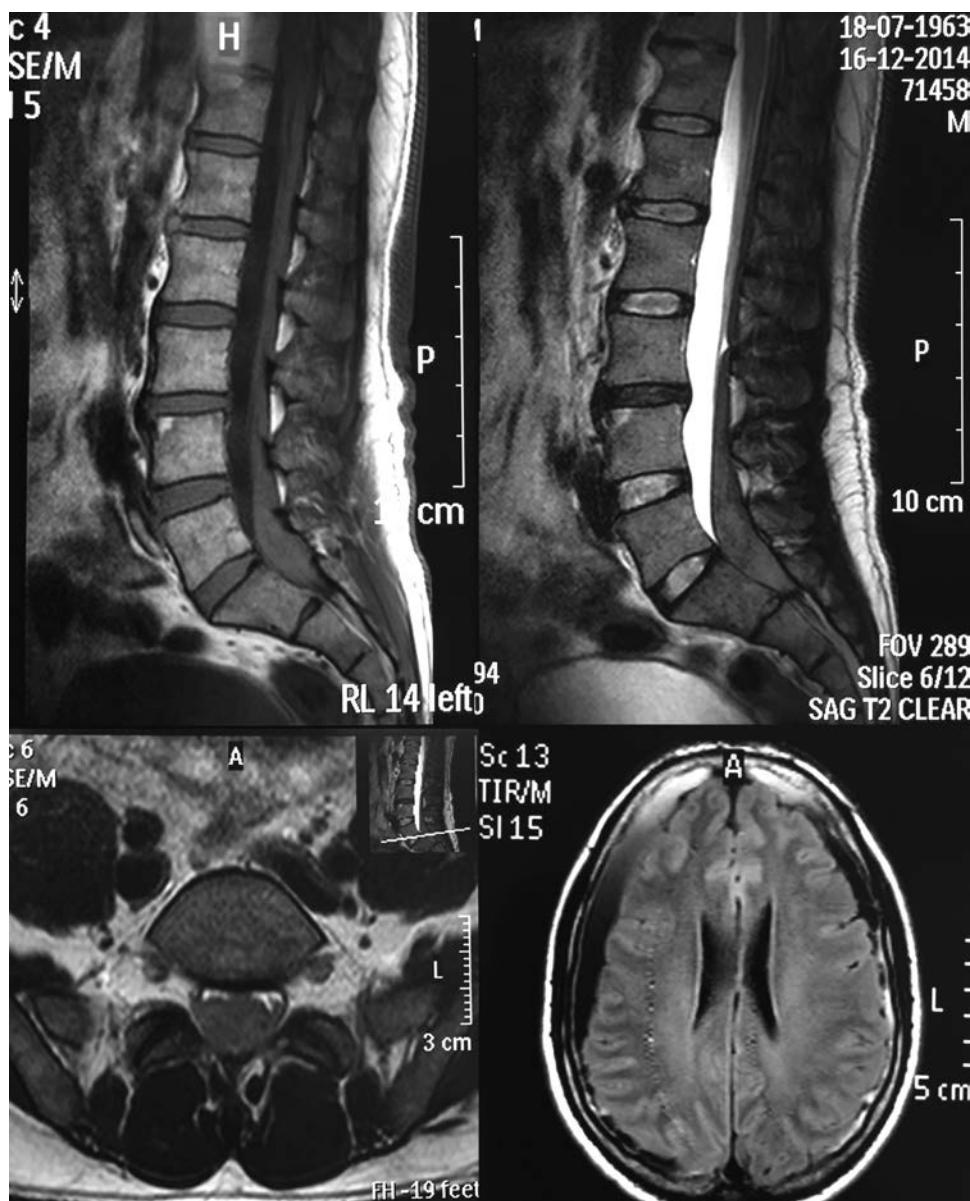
(A and B) T1 and T2-weighted magnetic resonance imaging of the lumbar spine showing a subdural hematoma in L3-S2. (C) Axial T1-weighted sequence showing the lumbar subdural hematoma. (D) FLAIR sequence revealing a bilateral brain subdural hematoma. Abbreviations: FLAIR, fluid attenuation inversion recovery.
